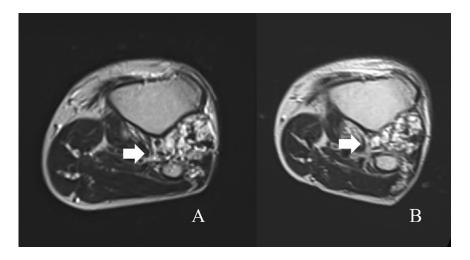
Case 2. MRI imaging prior (A) and 3 months (B) after Sirolimus therapy. Axial cuts in T2 sequence showing an extensive hyperintense lesion (venous malformation) extending to the anterior compartment of the leg. The area of the lesion was decreasd after Sirolimus therapy.
